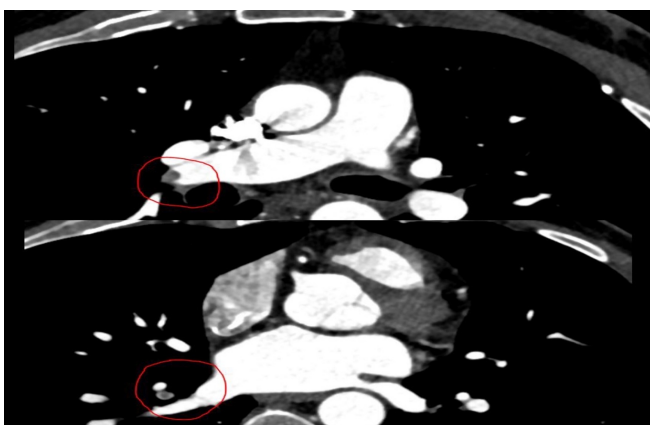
PTE compatible image seen on coronary Angio computer tomography (CT) of the patient. The patient's coronary CT showed no lesions in the coronary arteries. However, embolism was observed in the right main pulmonary artery and the branch
